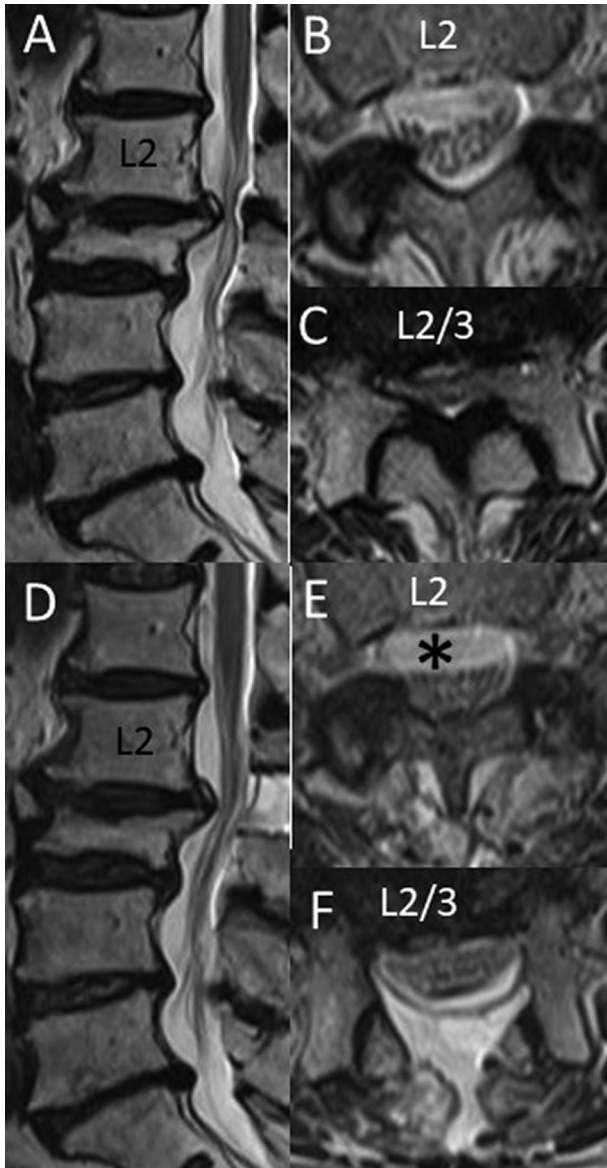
Preoperative and post-1st operative MRI of lumbar spine. (A–C) Preoperative T2-weighted MRI demonstrating the L2/3 canal stenosis with L3 collapse. (D–F) Postoperative T2-weighted MRI demonstrating the ventral SSEH 8 days after surgery (black asterisk). There were no appearance of herniated cauda equina fibers. MRI: magnetic resonance imaging, SSEH: spinal subdural extra-arachnoid hygroma.
